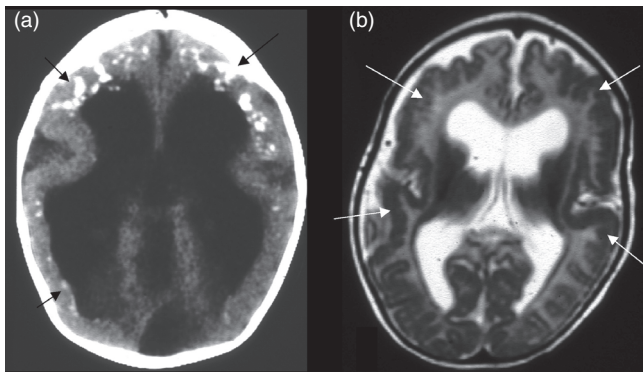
Congenital CMV: (a) calcification (arrows) on CT; (b) diffuse polymicrogyria (arrows) on axial T2 MRI.
